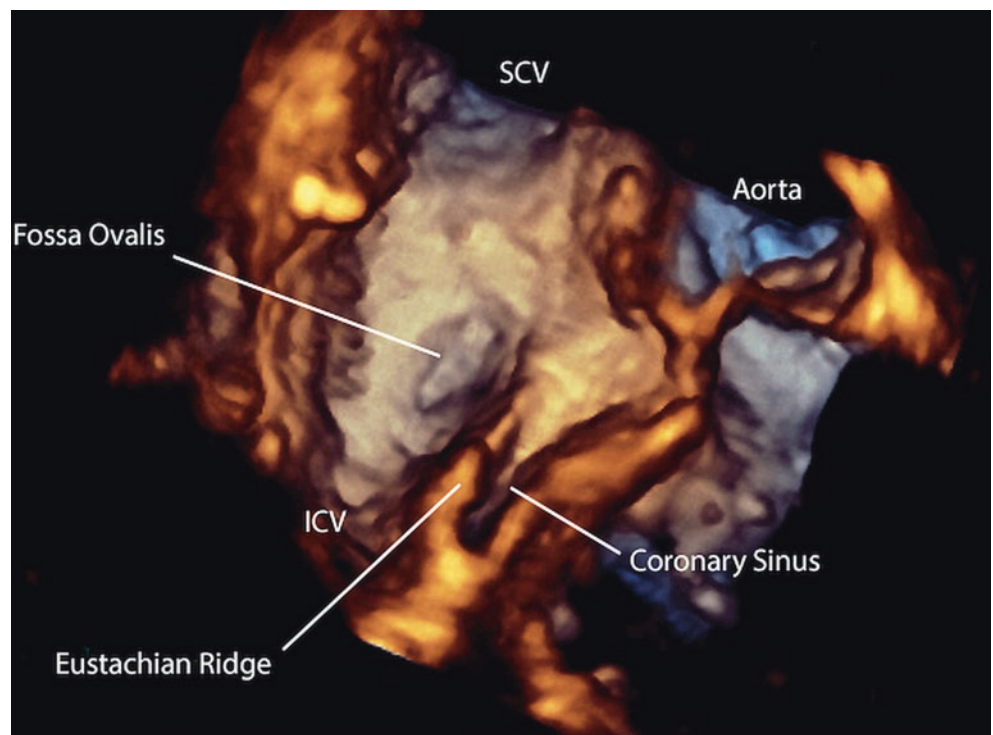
Eustachian valve displayed from a transthoracic subcostal acquisition, demonstrating its relation with the inferior cavae vena (ICV), Eustachian ridge, superior cavae vena (SCV) in a, and coronary sinus in b
